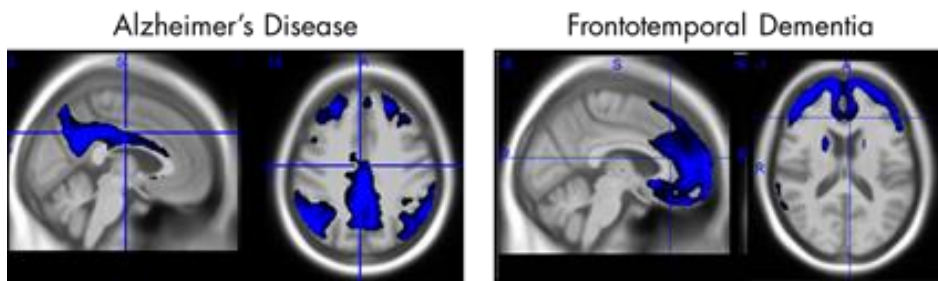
Metabolic patterns on FDG PET distinguishing AD and FTD
